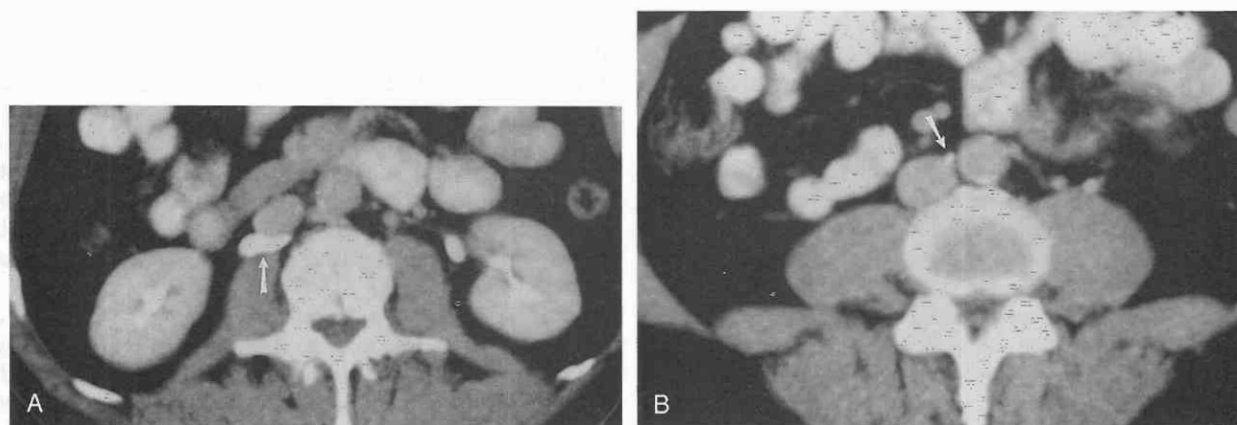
Circumcaval ureter. *A*, CT scan demonstrates the proximal portion of the right ureter (arrow) posterior to the inferior vena cava as it courses medially from the ureteropelvic junction. *B*, On a slightly more caudal image, the ureter (arrow) is located quite medially before continuing inferiorly in its more normal lateral position.
